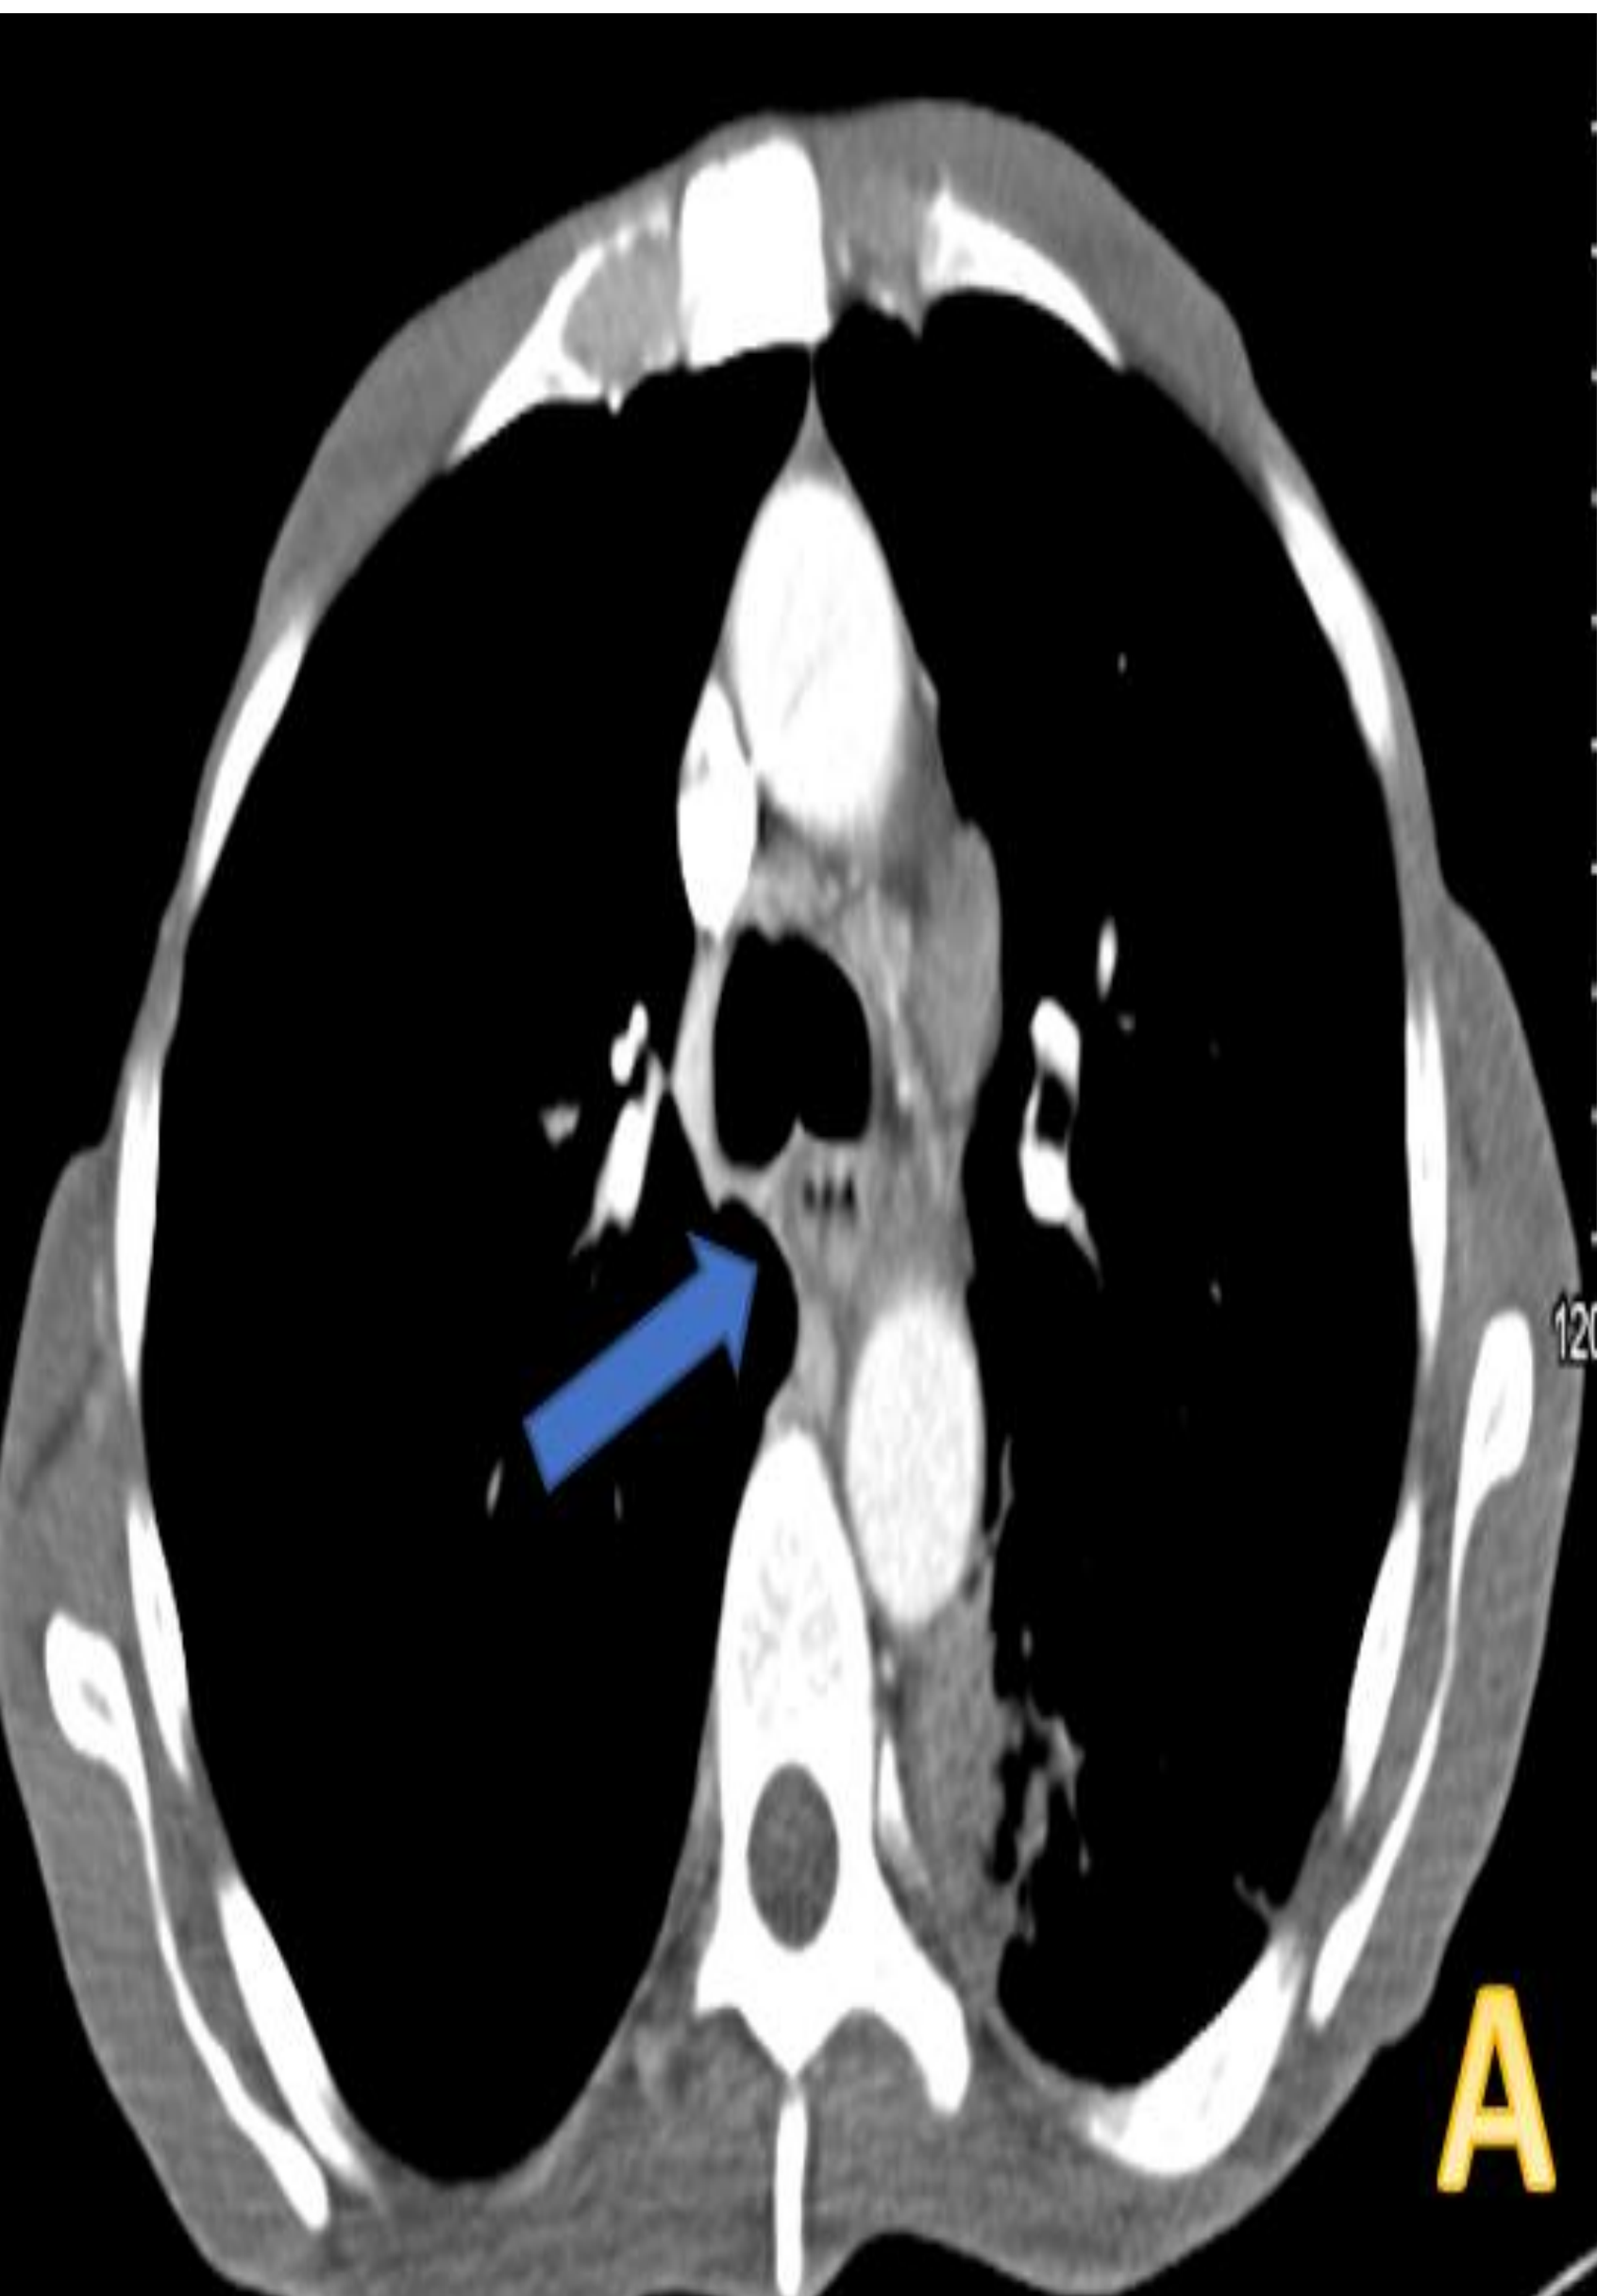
A demonstrates the CT scan finding of esophageal wall thickening
